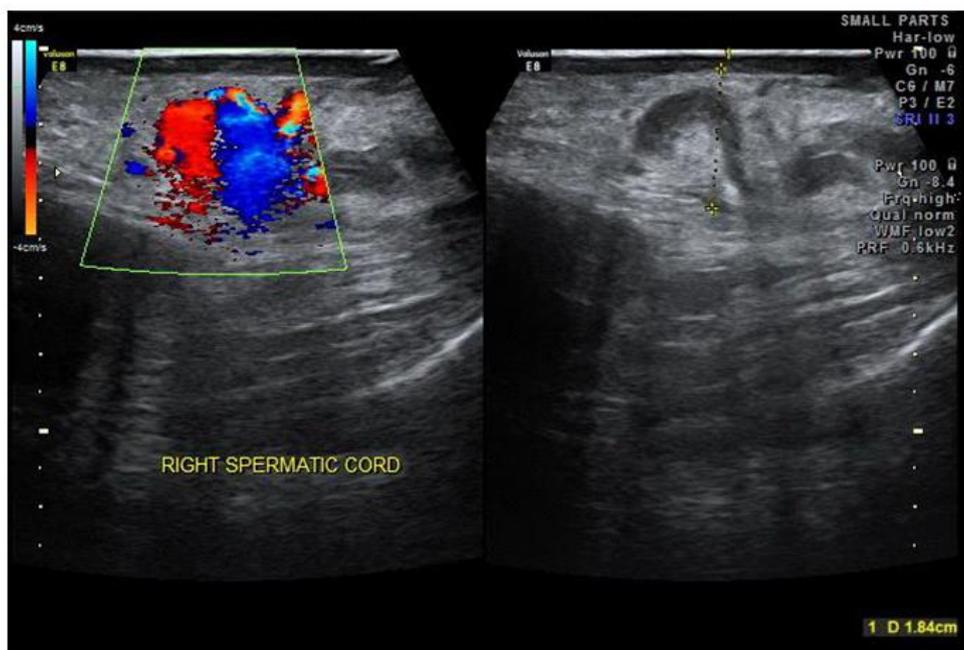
In above image -Right spermatic cord thickened and Heterogeneous in echo texture with Increased vascularity on color doppler study.
